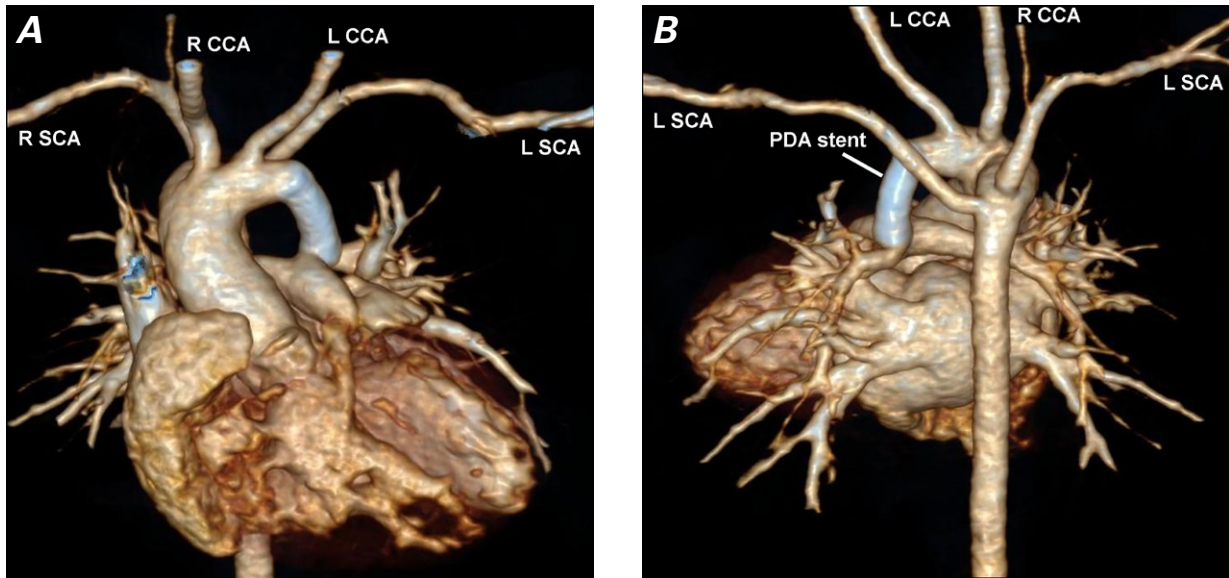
A) Multidetector computed tomographic angiogram shows the aortic arch abnormality before stent implantation. The left aortic arch branches into the common carotid arteries and ends with the patent ductus arteriosus. B) After stent implantation, the right aortic arch branches into the subclavian arteries and continues into the descending aorta.
